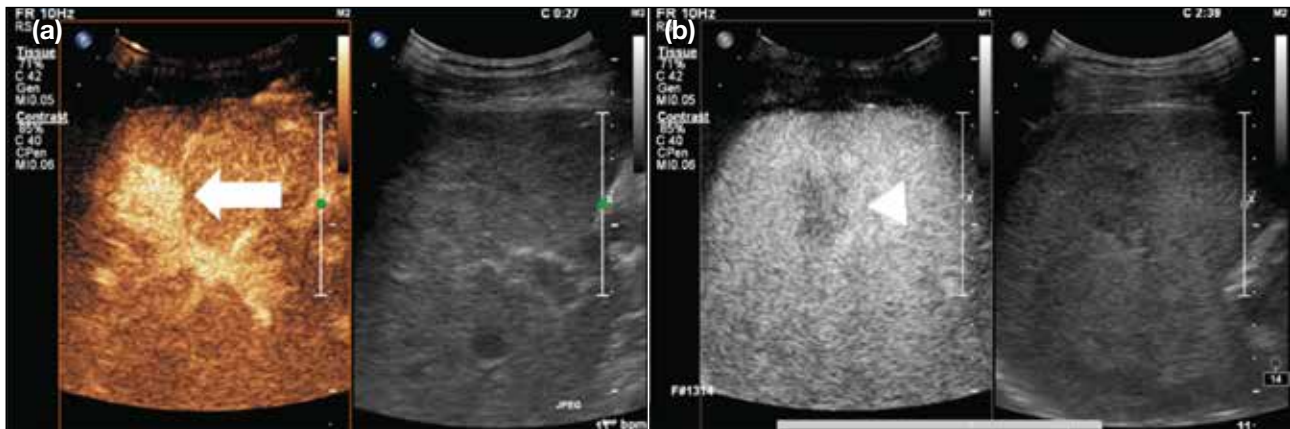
Case of typical hepatocellular carcinoma. (a) Contrast-enhanced ultrasound (CEUS) with SonoVue showed non-rim arterial phase hyperenhancement of the target lesion in segment V of liver (white arrow). The lesion measured 2.8 cm in maximal diameter (not shown). (b) In the late phase, this lesion demonstrated mild contrast washout (white arrowhead). This lesion was classified as CEUS LR-5 lesion (i.e., definitely hepatocellular carcinoma) according to the CEUS Liver Imaging Reporting and Data System version 2017.
